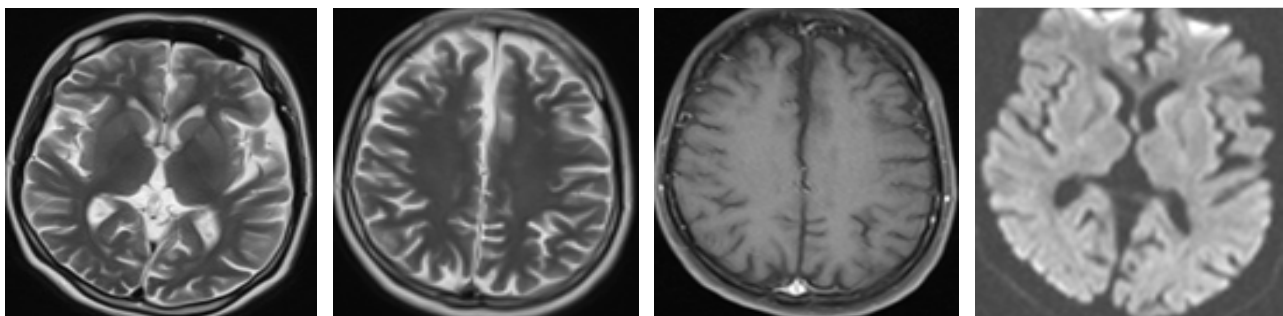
The first magnetic resonance imaging (MRI); No obvious abnormality was seen
